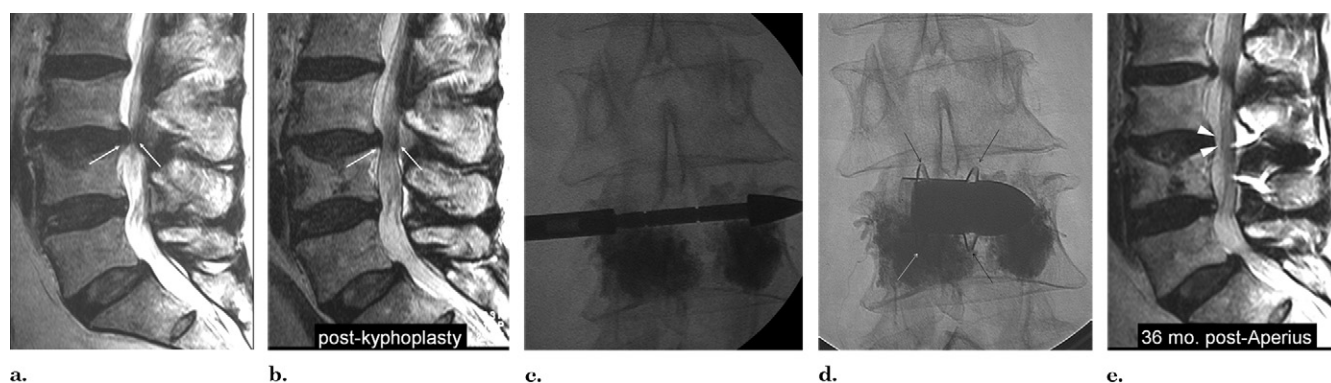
Patient 1. (a) Midsagittal T2 fast spin echo MR image shows L4 compression fracture, mild retropulsion of the superior corner of the posterior wall, and disk protrusion, resulting in severe central canal stenosis at L3-L4 (arrows). Short tau inversion recovery images (not shown) showed bone marrow edema in the fractured vertebral body. (b) Corresponding midsagittal T2 fast spin echo MR image after L4 kyphoplasty shows significant reduction of the segmental stenosis (arrows). (c) Anteroposterior fluoroscopic image during percutaneous interspinous dilator insertion. (d) Through the path created by the dilator, the Aperia IS device is percutaneously inserted between the spinous processes and released; four little wings (arrows) are opened, which, with the intact supraspinous ligament, secure the device in place. (e) MR imaging midsagittal T2 fast spin echo obtained at 36 months' follow-up shows further significant reduction of the spinal stenosis, with patency of the subarachnoid space and decompression of the roots of the cauda equina (arrowheads).
